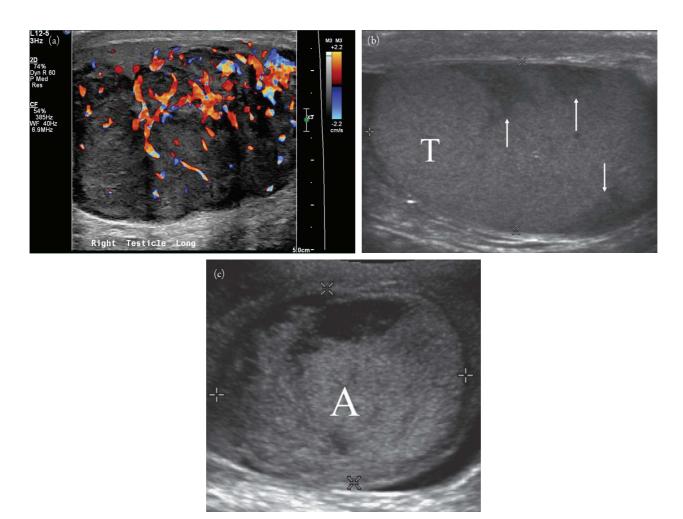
(a) Testicular tumor with increased vascular flow. (b) Testicular infarct secondary to trauma. Irregular, wedge-shaped hypoechoic areas (arrows) in a subcapsular location consistent with infarct following trauma. T = testis. Adapted from Figure 31 of Pearl MS, Hill MC. Ultrasound of the scrotum. *Semin Ultrasound CT MR.* 2007;28(4):225–248. doi:10.1053/j.sult.2007.05.001. (c) Testicular abscess. A = abscess. Adapted from Figure 29 of Pearl MS, Hill MC. Ultrasound of the scrotum. *Semin Ultrasound CT MR.* 2007;28(4):225–248. doi:10.1053/j.sult.2007.05.001.
